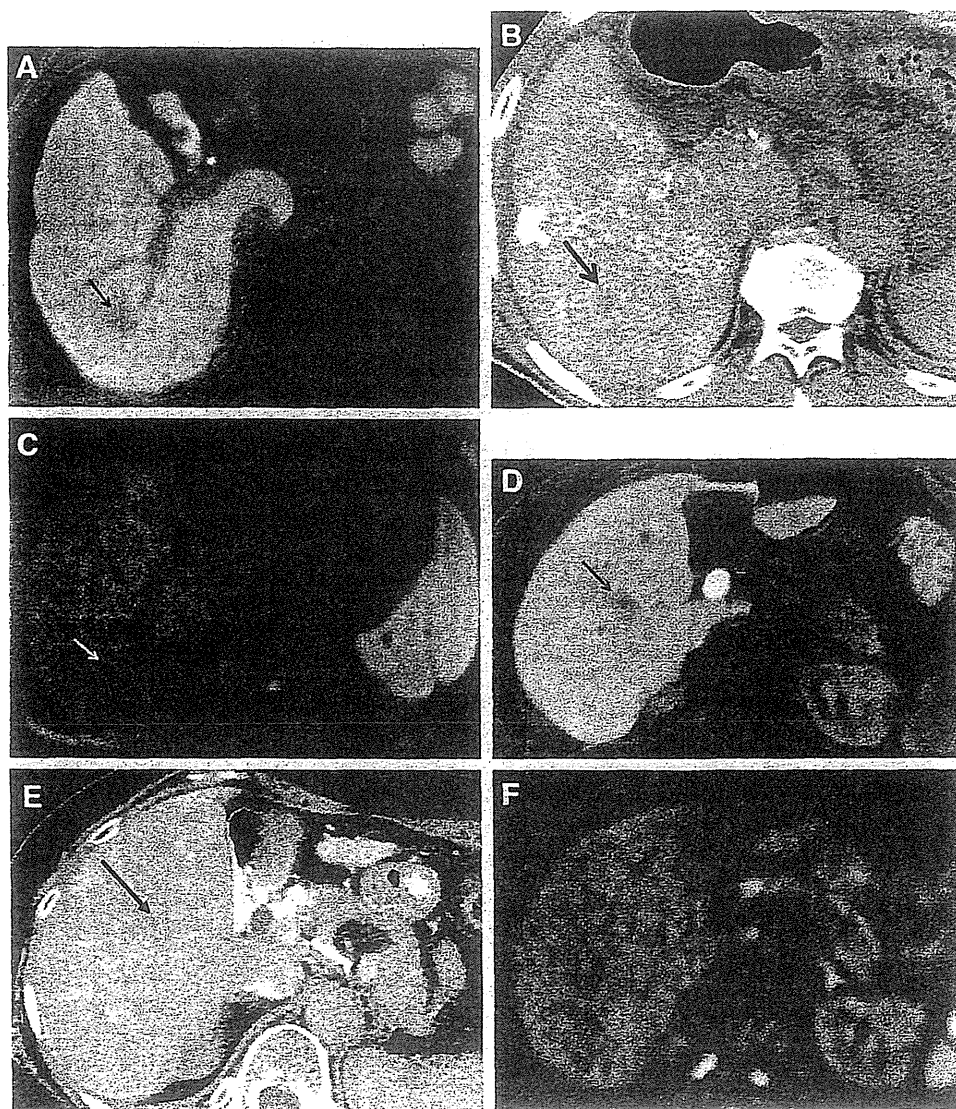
(A–C) A lesion in a 73-year-old man who remained nonvascular after 429 days from the initial diagnosis. (A) Hepatobiliary phase on Gd-EOB-DTPA-enhanced MRI shows a hypointense lesion on S6 (arrow). (B) CTHA shows a low-density area on S6 (arrow). (C) DWI shows a hypointense lesion (arrow). (D–F) A lesion in a 74-year-old woman who remained nonvascular after 1073 days from the initial diagnosis. (D) Hepatobiliary phase on Gd-EOB-DTPA-enhanced MRI shows a hypointense lesion on S5 (arrow). (E) CTHA shows a low-density area on S5 (arrow). (F) DWI shows isointense lesions.
